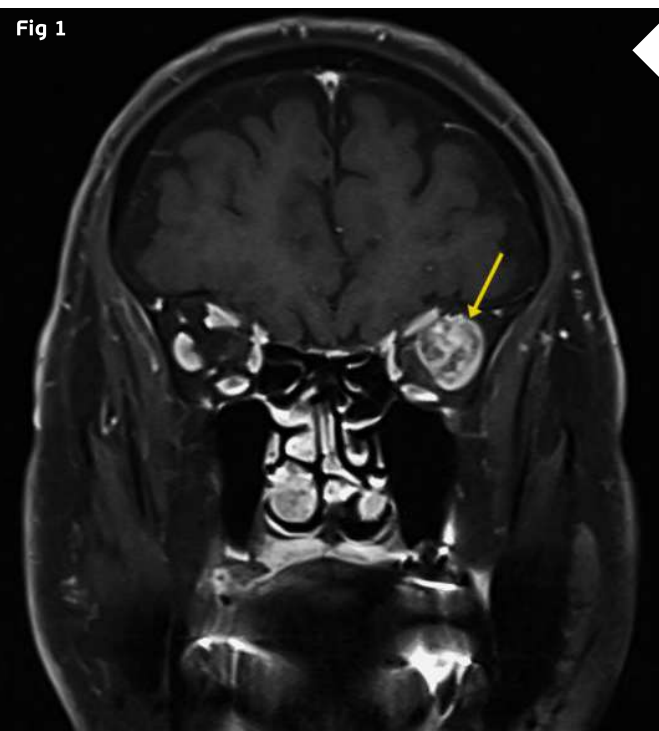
Coronal magnetic resonance T1-weighted imaging (T1-MRI) of the skull showing a roundish mass at the temporal aspect of the left orbit (arrow), with a highly heterogeneous intensity pattern, without apparent disruption of the orbital walls.
